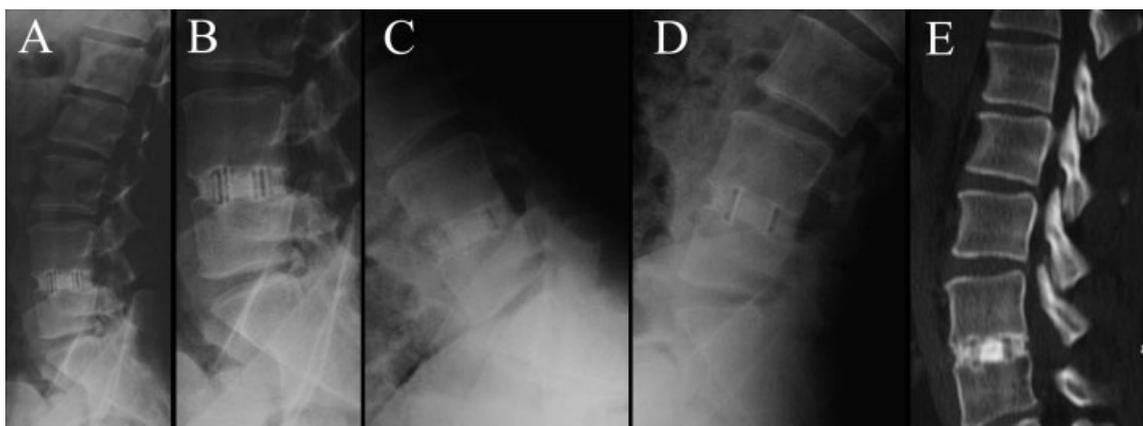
Case 2. Solid fusion in a silicate calcium phosphate (SiCaP) case at 36-month follow-up. (A) Lumbar spine, lateral x-ray. (B) L4/L5 segment, lateral x-ray. (C) Flexion lateral x-ray. (D) Flexion lateral x-ray. (E) Sagittal view of a computed tomography scan.
